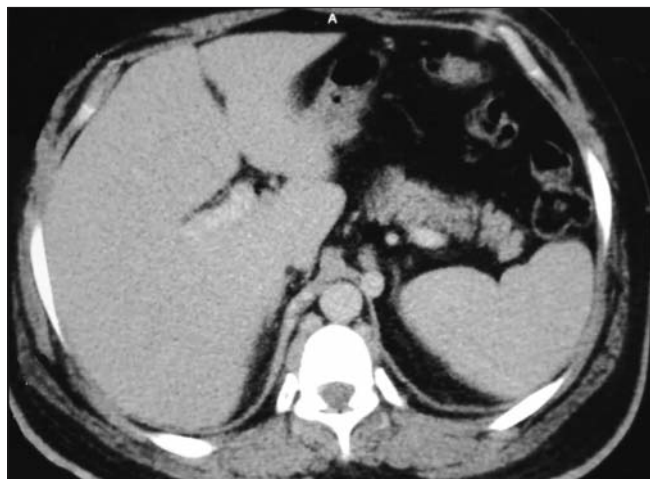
CT scan – axial plane (personal archive)
